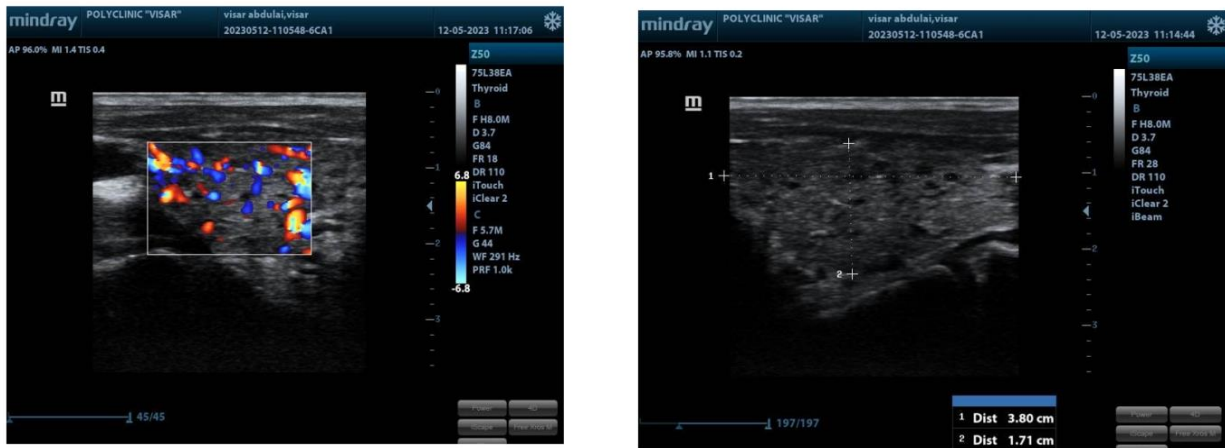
Ultrasonography of thyroid gland conducted by a specialist endocrinolog (Dr.Spec.Irfan Ahmeti-Albimedica, 2025)
